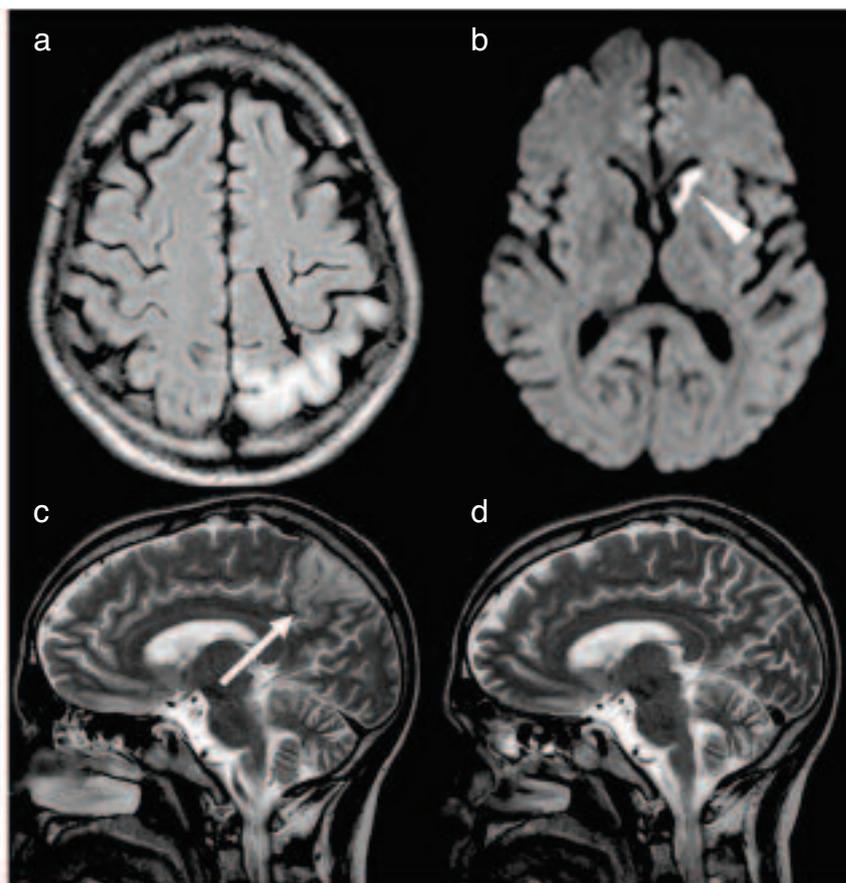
Magnetic resonance and diffusion-weighted imaging of the brain at diagnosis and follow-up. At diagnosis, fluid-attenuated inversion recovery (a) and diffusion-weighted (b) axial, and T2-weighted sagittal (c) images show prominent cortical and subcortical swelling and high signal intensity (arrows) of the left parietal lobe, and high signal intensity of the head of the left caudate nucleus (arrowhead). Similar signal changes were present in the left temporal cortex (not shown). Additional findings included atrophy of the mammillary bodies (not shown). Twenty-one days later, T2-weighted sagittal (d) images show a clear cut reduction of the abnormal findings. Also in the left temporal cortex and in the head of the left caudate nucleus the abnormal findings regressed (not shown).
